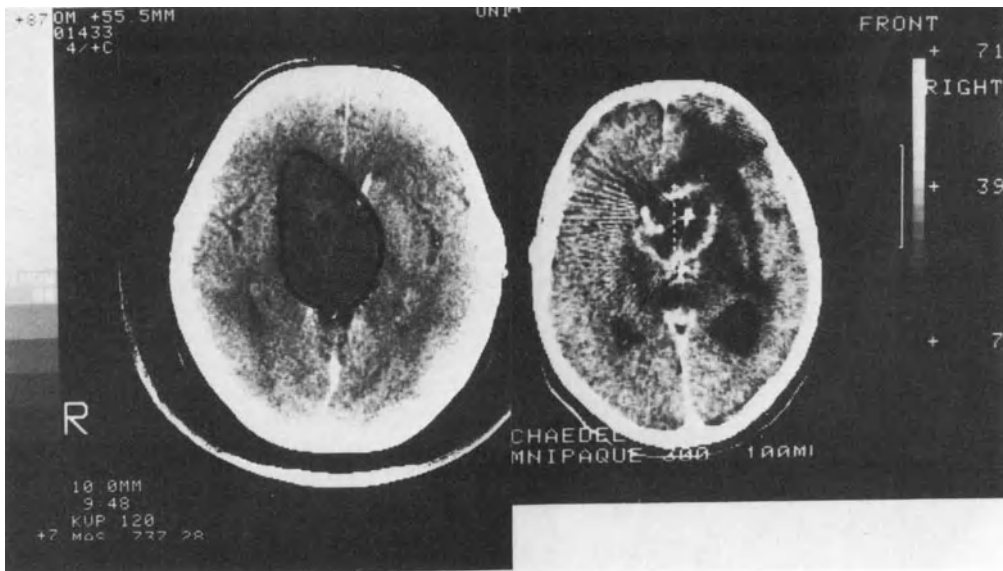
Extensive grade II fibrillary astrocytoma in a 33-year-old patient. The tumor bilaterally involves the diencephalon and infiltrates the right posterior frontal lobe and corpus callosum. (Left) CT scan defines tumor extent and mainly shows a hypodense mass (hatching) prior to Curietherapy. (Right) CT image $1\frac{1}{4}$ years after ^{125}I Curietherapy. The tumor has regressed significantly. The ^{125}I seeds can be seen in the center. A thin hyperdense "halo" is noted with contrast enhancement, and the center is hypodense (necrotic). Hypodense focal reactions (gliosis?) are seen mainly in the right frontal and mediotemporal regions. A dramatic improvement in the clinical findings occurred. The patient was essentially neurologically asymptomatic and capable of working.
